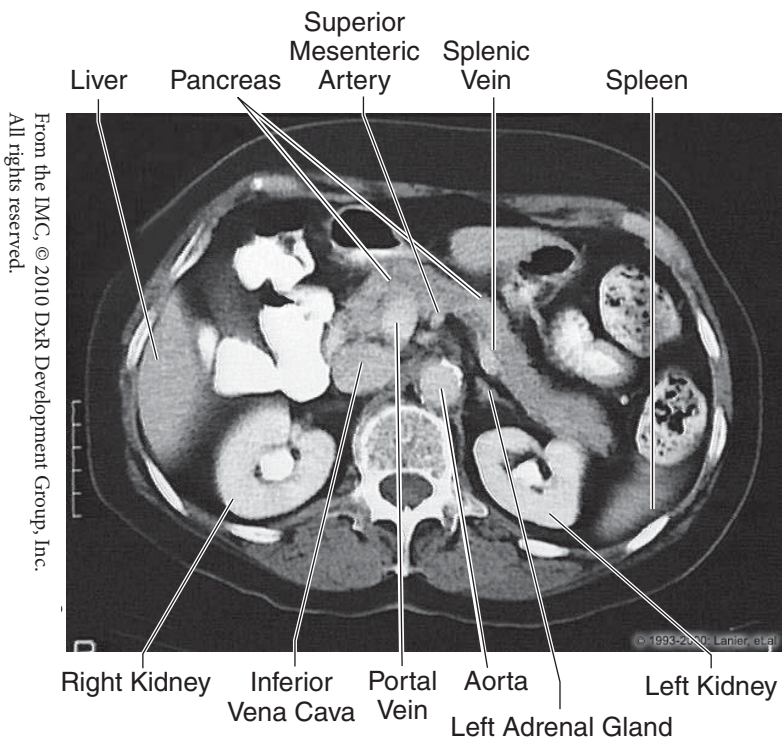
Abdomen: CT, L1
